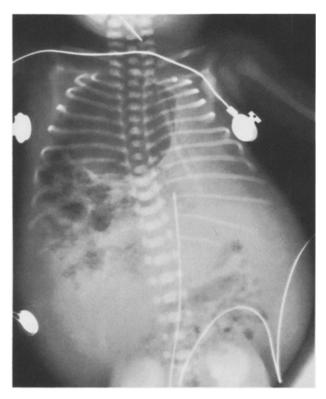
Antero-posterior radiograph of the infant's chest and abdomen at one hour of age demonstrates large lucent mass in the right hemithorax with shift of mediastinal structures to the left. Ascites is evident
